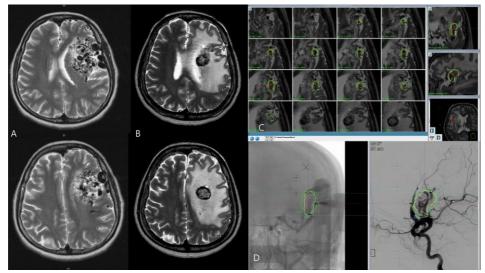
A 39-year-old woman (case 4) presented with seizure. A) MRI scan showed large AVM on the left parietal lobe. She underwent repeated GKRS. B)
